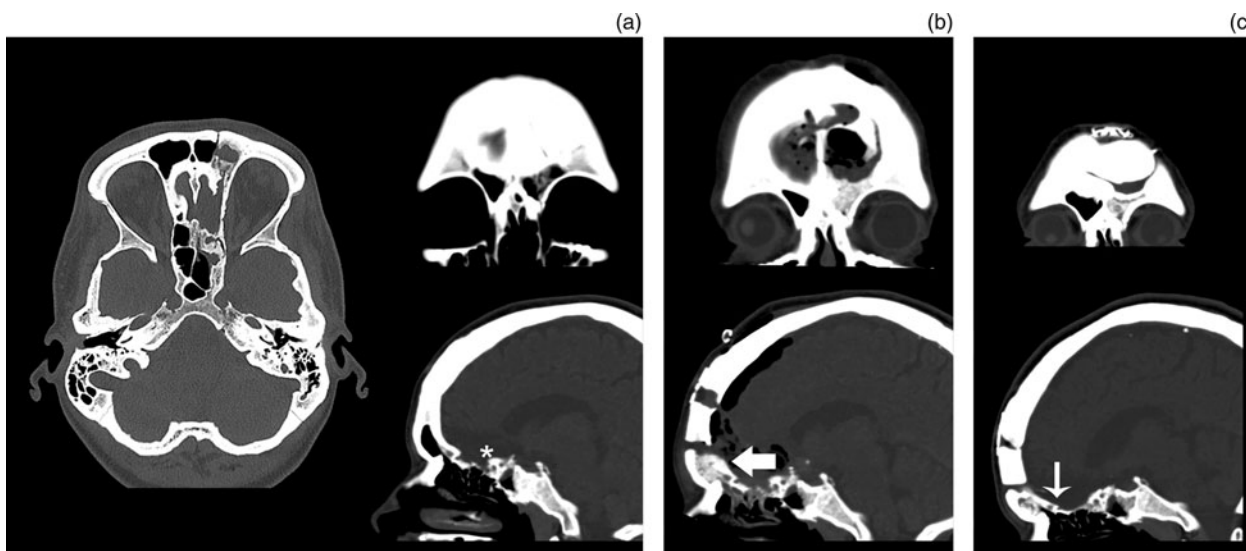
Patient 3 – non-contrast, coronal and sagittal computed tomography bone window images of the left-sided frontal sinus fracture with extension to the anterior skull base (ethmoid) (asterisk): (a) pre-operatively (axial view), (b) day 1 post-operatively and (c) 6 months post-operatively, demonstrating osseous integration (large arrow) of the beta-tricalcium phosphate putty obliterating the left frontal sinus and sealing the anterior skull base defect posteriorly (thin arrow).
